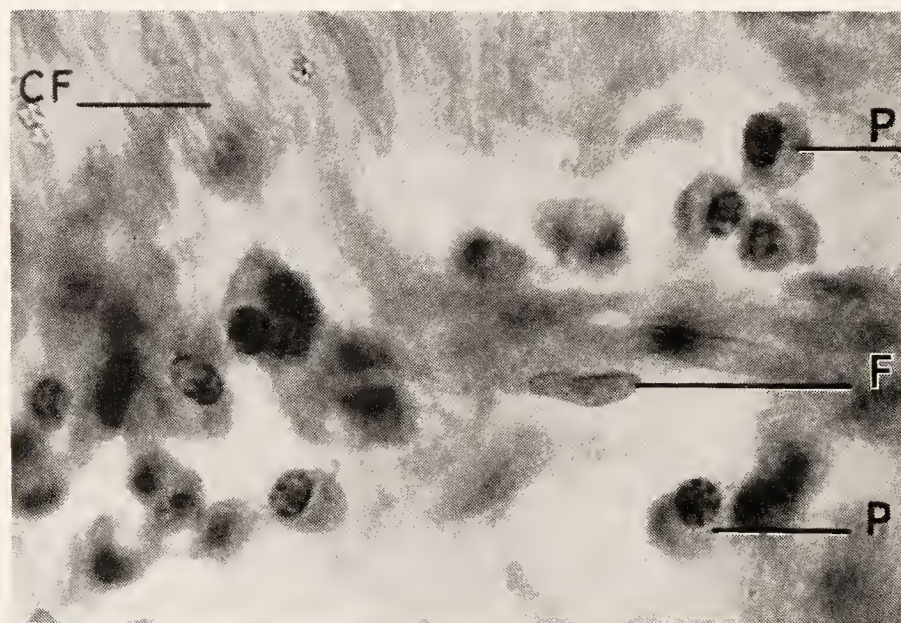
Typical cell forms in case of chronic inflammation of the periapical tissue. P, plasma cells (polyblasts) with "cartwheel" nuclei; F, fibroblast; CF, connective tissue fibrillæ.
